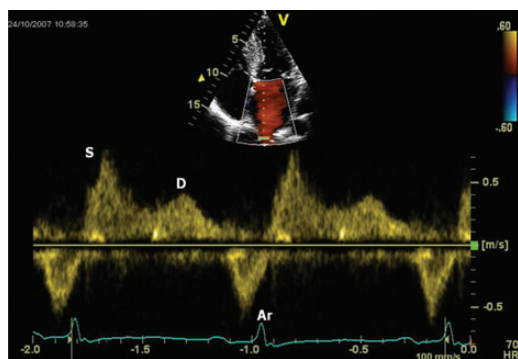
Methodology of measurement of pulmonary venous flow velocity. Pulmonary venous flow pattern obtained by pulsed Doppler sample volume at 0.5 cm into the right upper pulmonary vein. AR, atrial reverse velocity; D, early diastolic velocity; S, systolic peak velocity.
